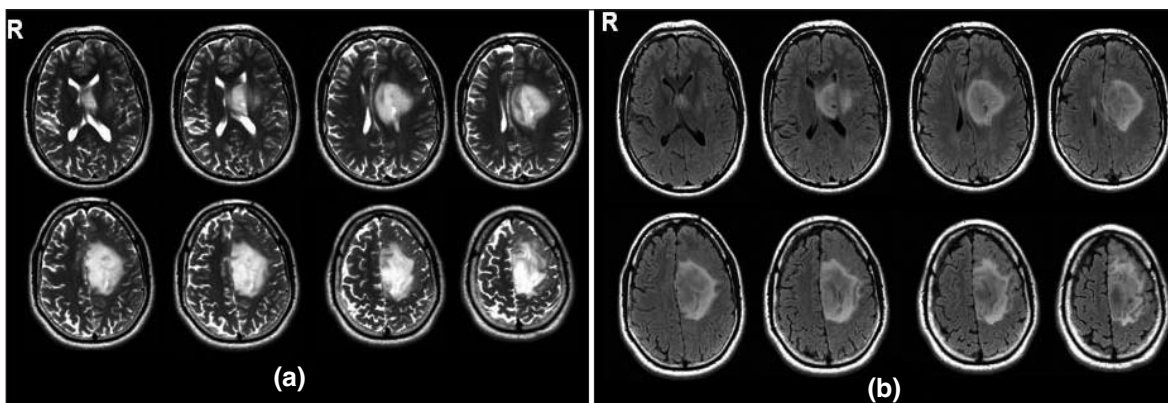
Anatomical localization of the brain lesion as assessed by T2-weighted (panel a) and fluid attenuated inversion recovery scans (panel b). The large mass is located in the left lateral (middle frontal gyrus) and medial frontal lobe (superior frontal gyrus, sub-genu and cingulate cortex), and causes a shift to the right of the midline and compression of the body of the corpus callosum. See text for further details.
